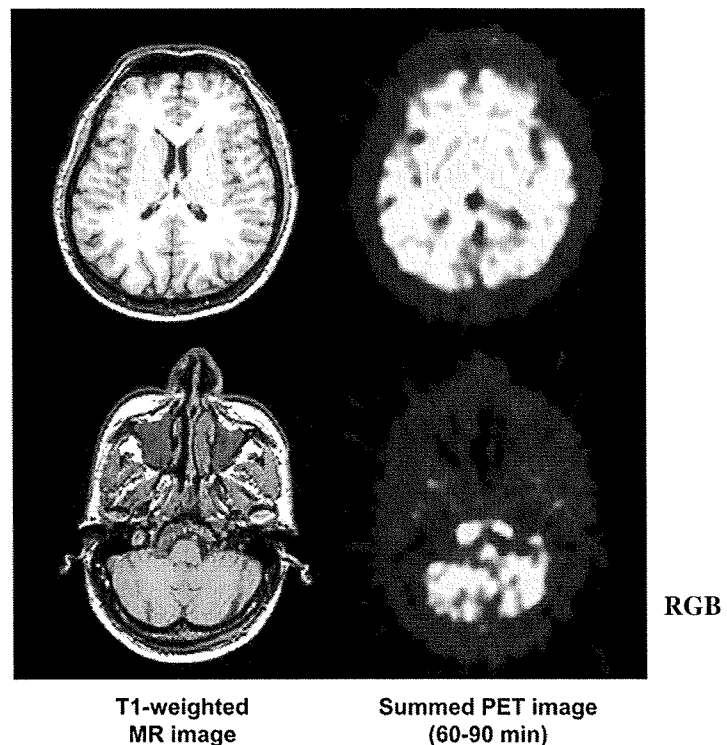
Representative summed PET images 60–90 min after intravenous injection of <sup>11</sup>C-MNPA (221 MBq) and corresponding T1-weighted MR images in control human subject. Upper panel shows horizontal section through striatum, and lower panel shows section through cerebellum.
